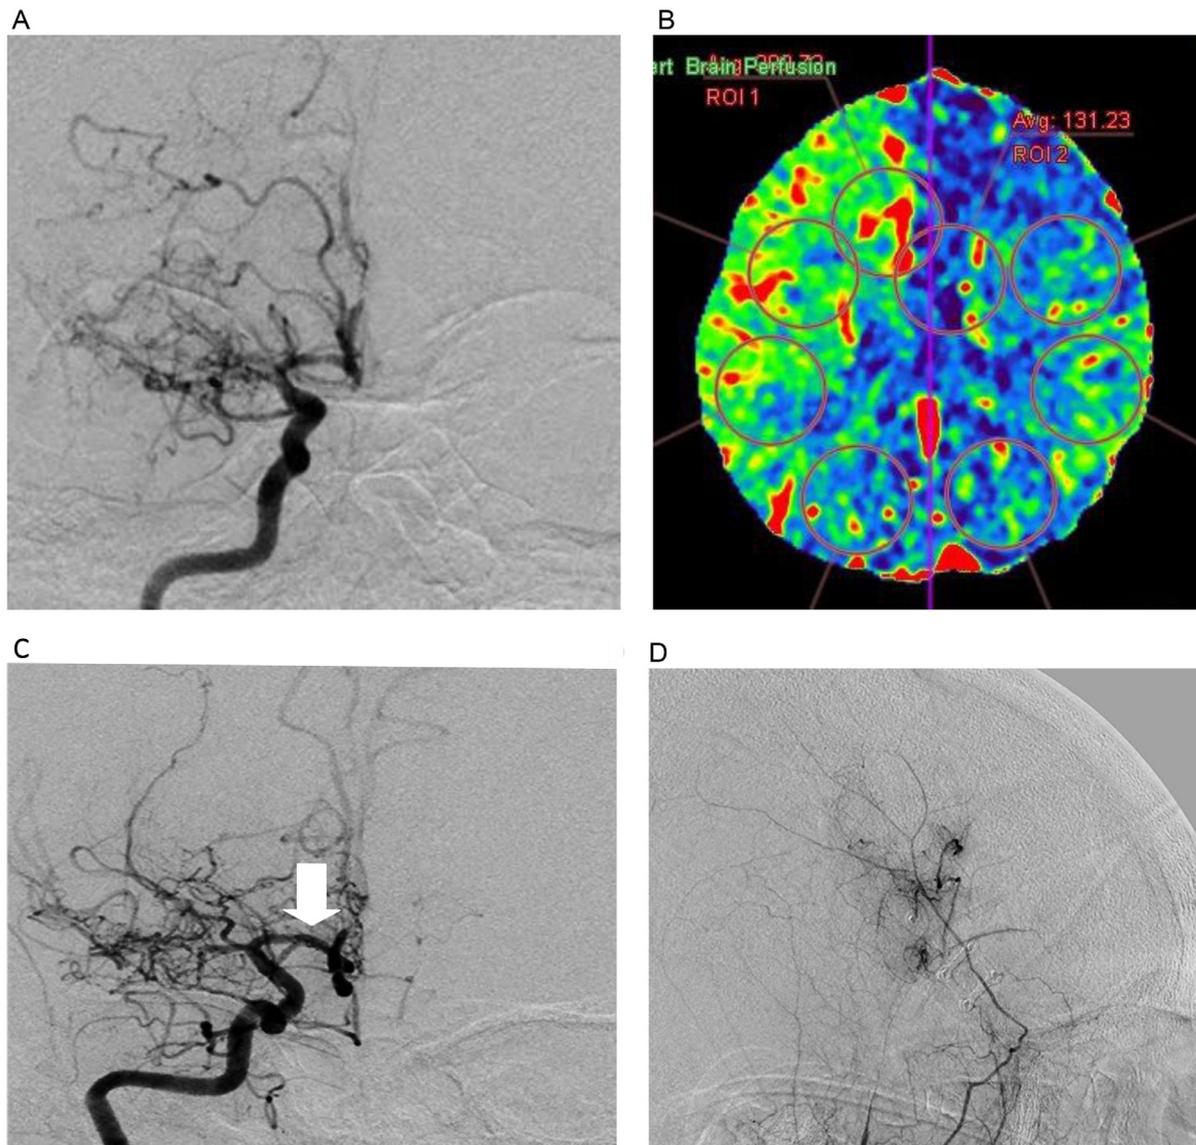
(A) Right ICA angiogram, case #2: occlusion of right MCA with robust moyamoya-type collaterals, and stenotic disease in right ACA. (B) TTP CT perfusion image, case #2: marked delay in right MCA territory. (C) 6-month follow-up right ICA angiogram, case #2: persisting steno-occlusive disease in right MCA, but improved caliber of proximal right ACA (white arrow). (D) 6-month follow-up right ECA angiogram, case #2: moderate brain revascularization via STA graft demonstrated.
